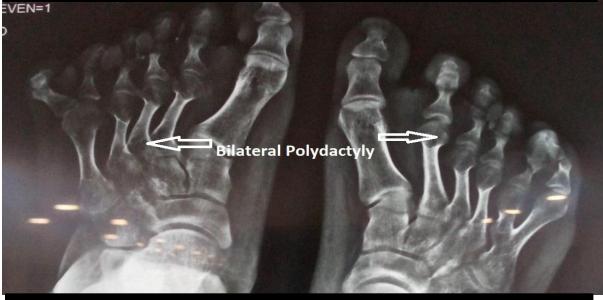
5 Radiograph showing bilateral polydactyly in the feet.
